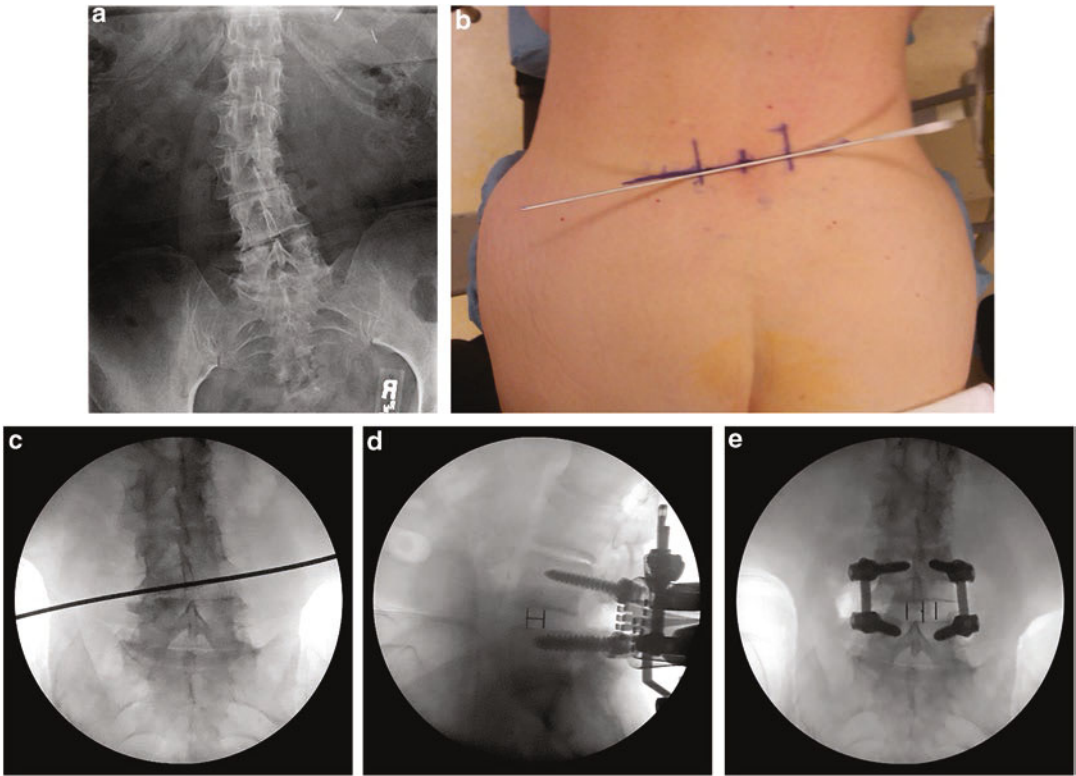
Severe coronal imbalance requiring an L4–L5 MIS TLIF. (a) Anteroposterior (AP) radiograph demonstrating the severe coronal imbalance (image has been flipped to match fluoroscopic images taken at surgery). (b) Preoperative photograph shows a Steinmann pin placed over the operative segment to plan the incisions and adjust the fluoroscope. (c) AP fluoroscope image
